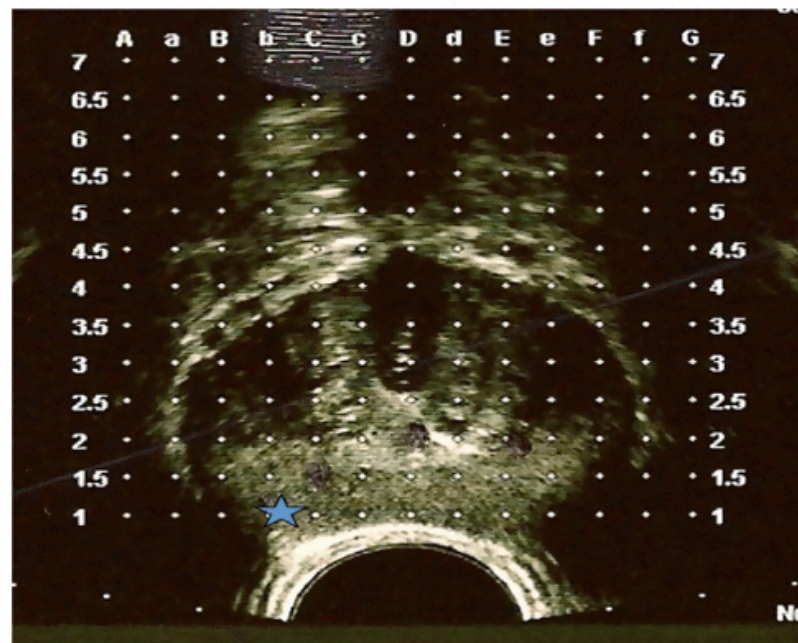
Ultrasound showing the brachytherapy grid overlay used during the 3D Prostate Mapping Biopsy. The star represents the area that was positive on this patient. Note that the positive area is in the region of the NVB.
